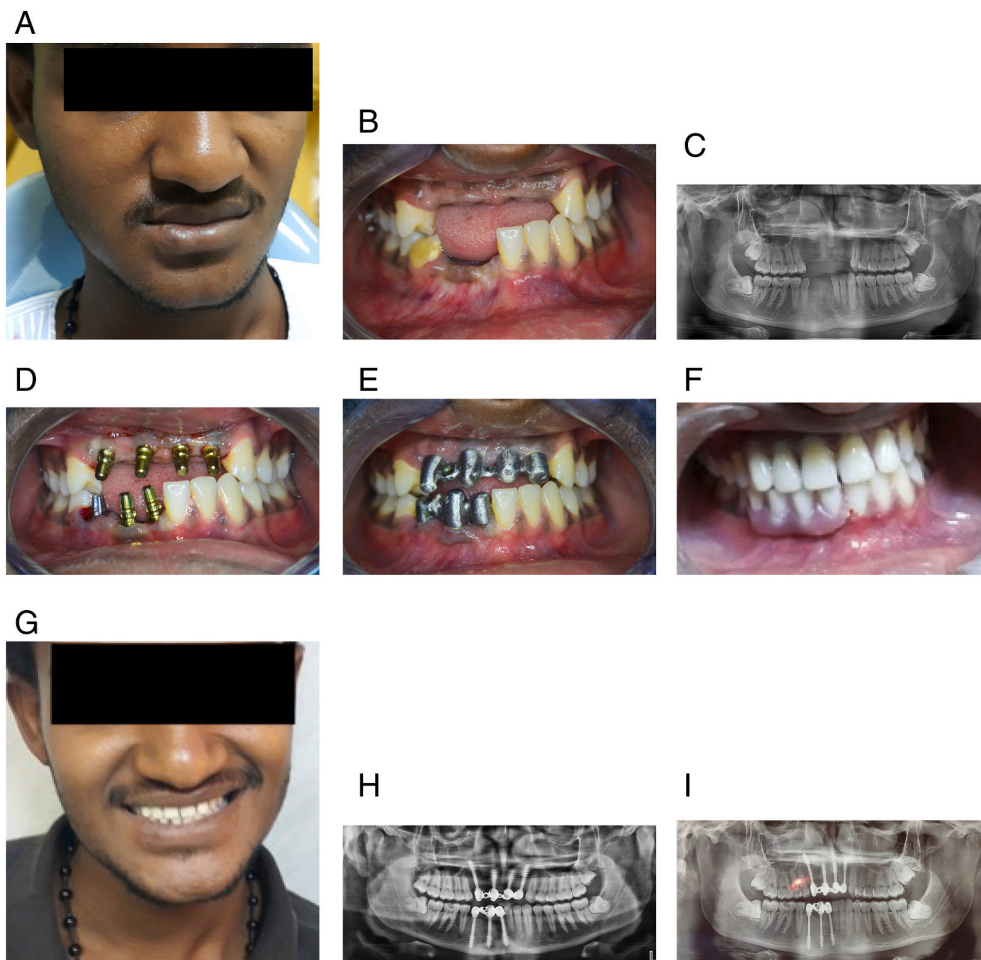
The patient's code 03 presentation. A. Patient's photograph presents his frontal view at the time of presentation. B. Intraoral view showing missing teeth number 13, 12, 11, 21, 22, 41, 42, and 43, and compromised bone support. Tooth 43 presents with a fractured crown. C. Panoramic view showing missing teeth numbers 11, 12, 13, 21, 22, 23, 41, 42 43. D. Intraoral view showing implant distribution. E. Panoramic view showing implant distribution. F. Extraoral view showing the metal frameworks on the casts. G. Intraoral view showing the metal frameworks on the patient's mouth. H. Final, fixed, immediately loaded corticobasal implant-supported prosthesis on the casts. I. Final, fixed, immediately loaded corticobasal implant-supported prosthesis inserted inside the patient's mouth. J. Patient's frontal view after prosthesis insertion. K. The intraoral view of the patient depicting his clinical presentation exhibiting optimal peri-implant oral health. L. A panoramic radiograph showing the prostheses after 5 years of function.
